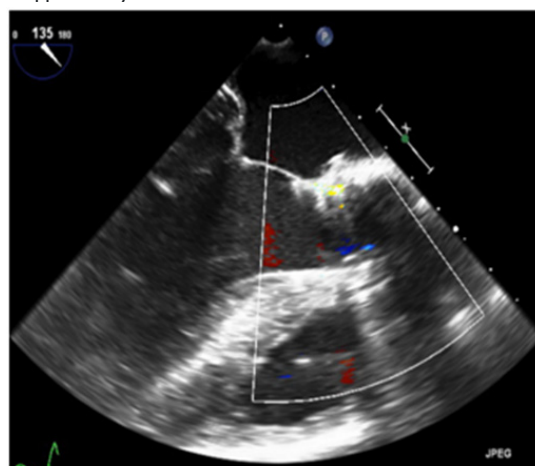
Echocardiogram showed a colored Doppler without aortic regurgitation.
